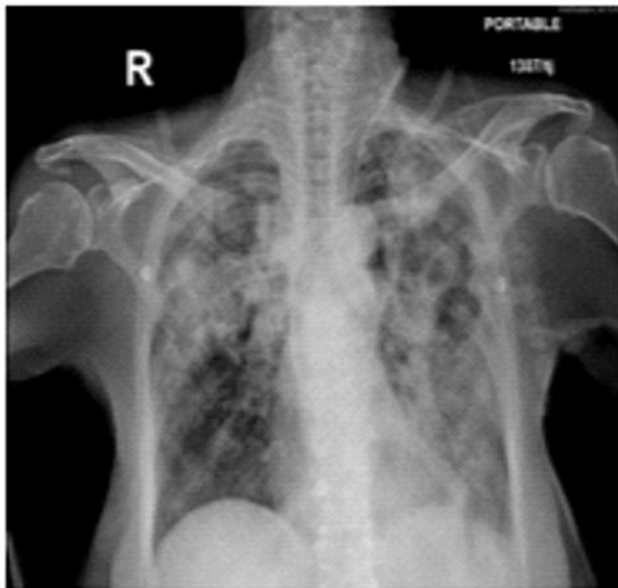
(b) – Chest X-ray- Dense consolidations seen bilaterally upper and mid zone right side and left lung field .Fig1.(c) Chest X-ray Post-Haemoptysis(Day 5) Bilateral consolidations seen suggestive of extensive Pulmonary tuberculosis
